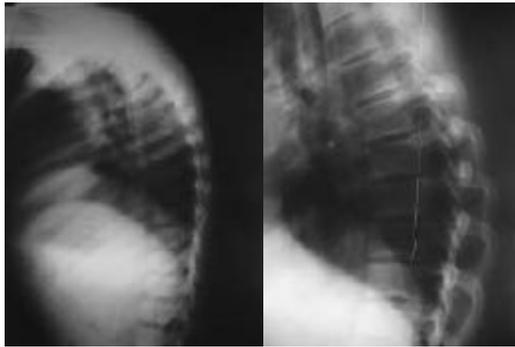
X-rays of Thoracic spine lateral views showing Round Back Deformity
